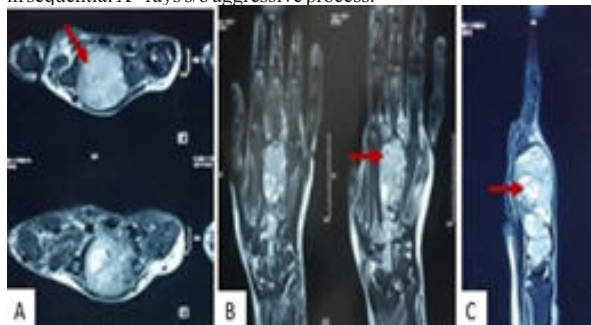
(A, B, C)- Axial, Coronal and Sagittal MRI images showing a lobulated heterogeneous signal intensity lesion involving 3rd metacarpal bone. Lesion also shows internal cystic component with fluid-fluid levels.
